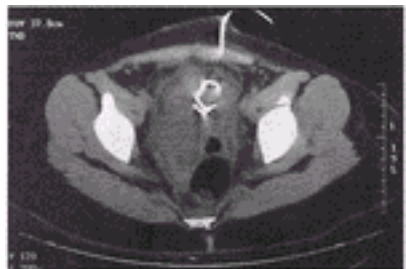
Computed tomography scans showing percutaneous placement of a pigtail catheter in an abscess after cesarean section. (From Sweet RL, Gibbs RS. Postpartum infection. In: Sweet RL, Gibbs RS. Infectious diseases of the female genital tract. Philadelphia: Lippincott Williams & Wilkins, 2002, with permission.)
